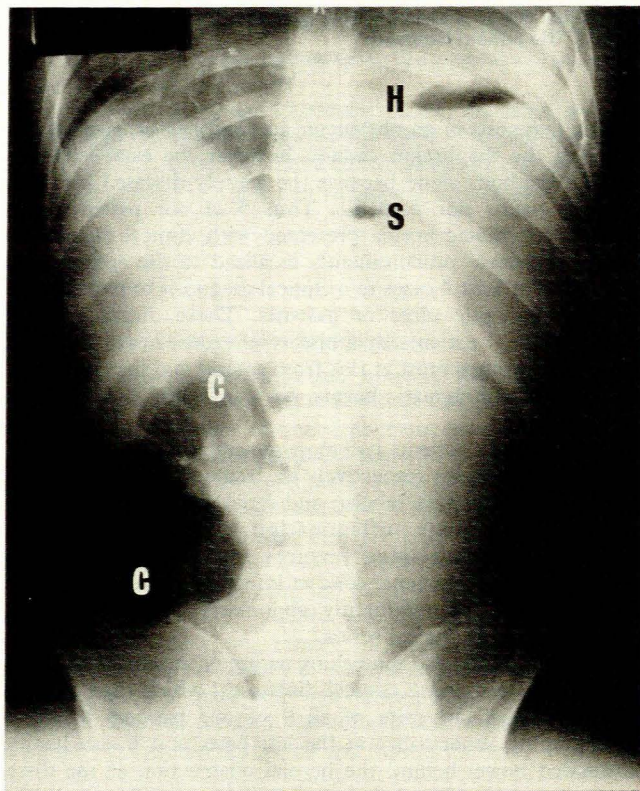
Case 4. Pre-radiography clinical diagnosis unknown. Post-radiography diagnosis: strangulated colonic hernia. Operation: strangulated, gangrenous colonic hernia. The patient died postoperatively. This chest radiograph shows a large, domed gas-fluid collection at left base due to the hernia, with pleural effusion.
